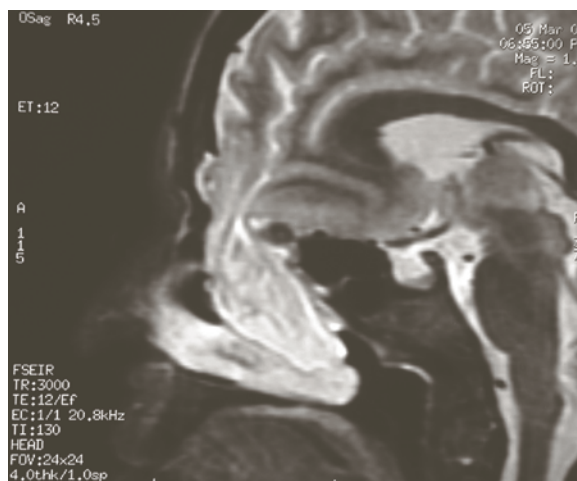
A coronal MRI scan of a right-sided meningocele seen on physical exam in Fig. 18.4 (Courtesy of Metin Önerci)
